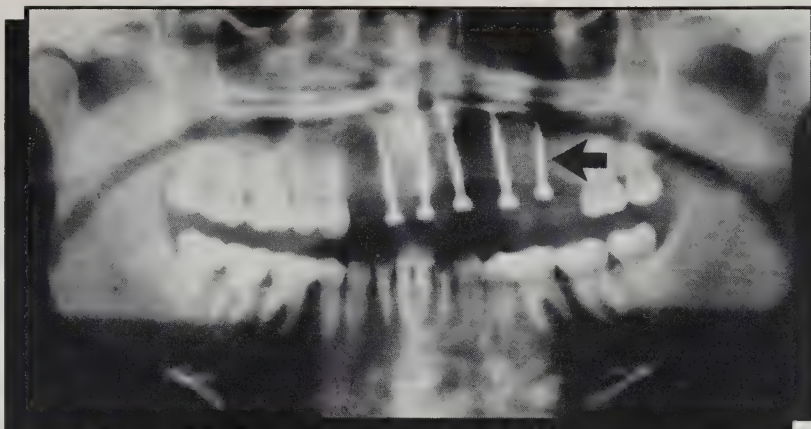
Panoramic radiograph following placement of implant fixtures. Note the placement of the posterior implant into the maxillary sinus (arrow) and placement of two of the anterior implants through the bony portion of the nasal fossae, as pictured on the anterior occlusal radiograph in Fig. 3b.
